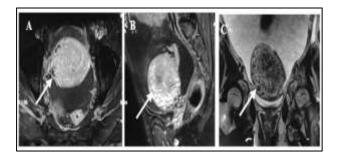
MRI images (A) T1 post-contrast axial. (B) T1 post-contrast sagittal and (C) T2 FS coronal showing the uterine mass (marked with white arrows).
